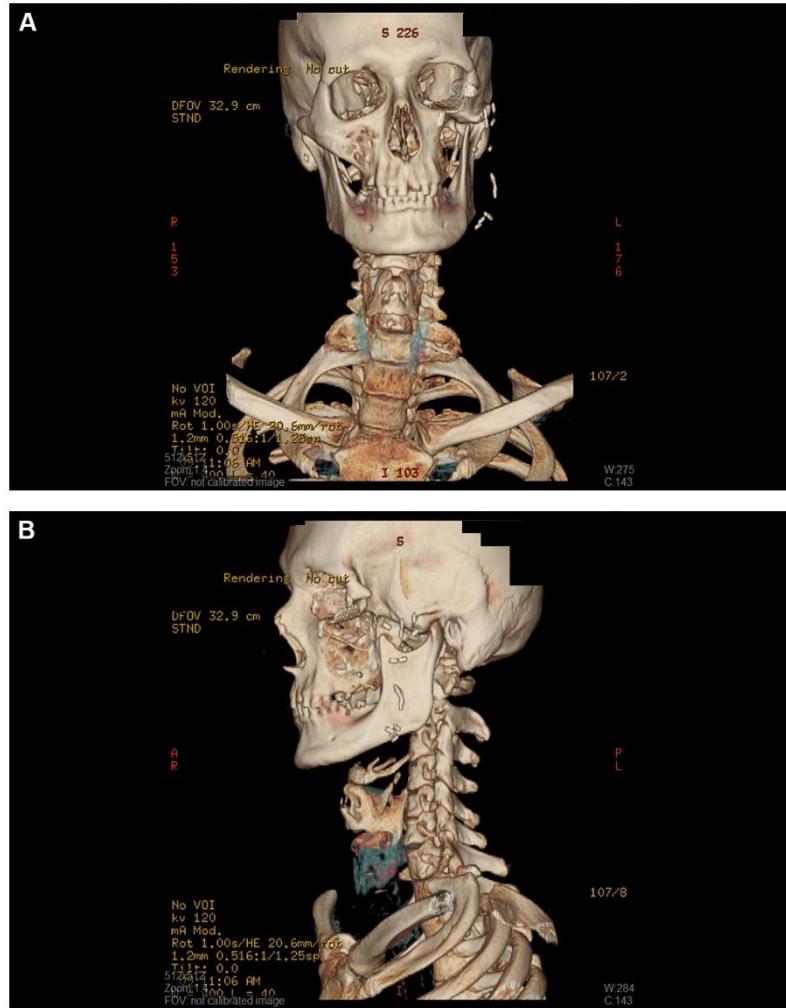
The tumor-free status revealed by CT 6 months after the operation.
